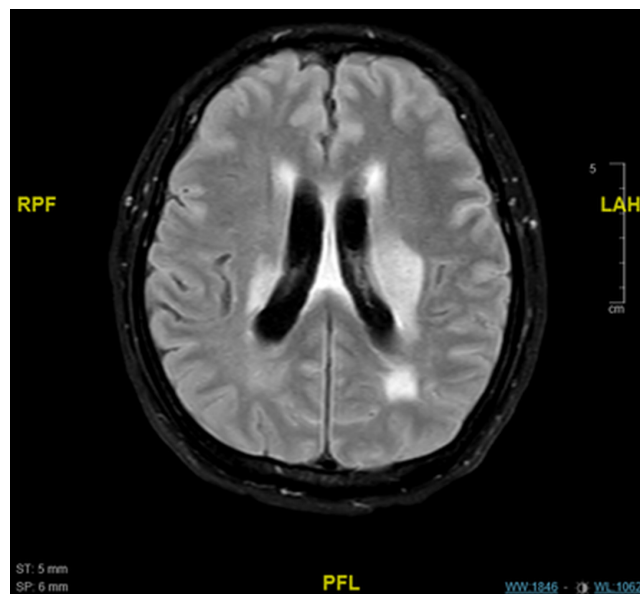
MRI Brain (FLAIR) showing multifocal infarcts with minimal leptomeningeal enhancement
